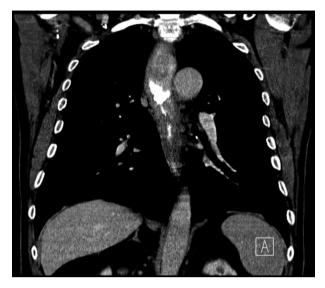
CT image of the stricture
